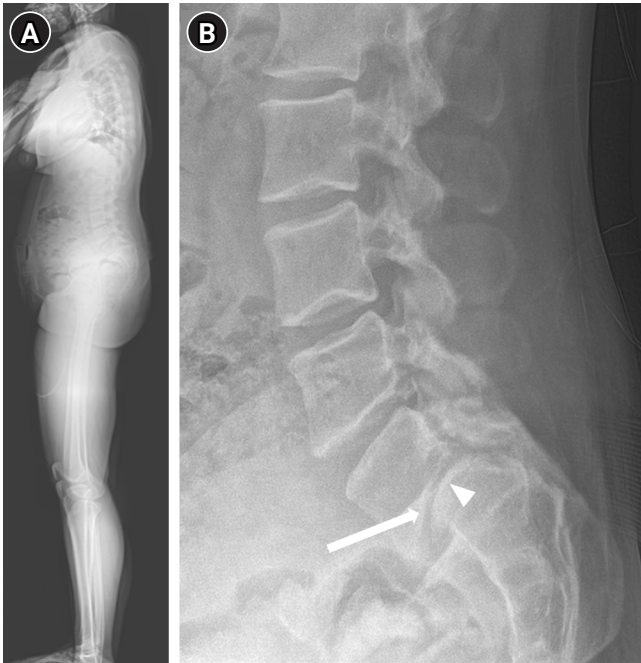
Whole-spine standing lateral radiograph and simple lateral radiograph demonstrating dysplastic spondylolisthesis at the L5–S1 level. (A) Whole-spine standing lateral radiograph showing a stooped sagittal posture, resulting in a characteristic appearance associated with high-grade L5–S1 dysplastic spondylolisthesis. (B) Simple lateral lumbar radiograph demonstrating high-grade anterior slippage of L5 on S1 (arrow) and sacral dome deformity (arrowhead).
